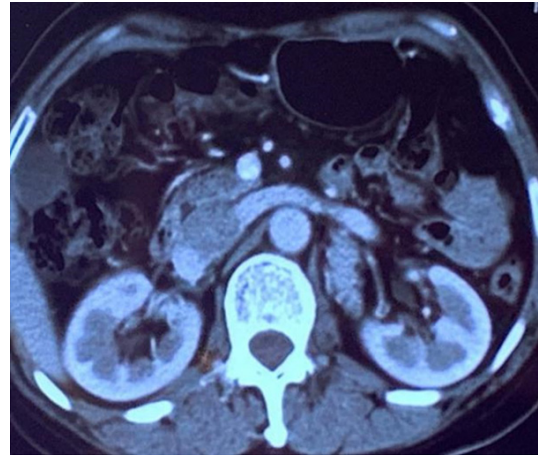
CT venous phase.
